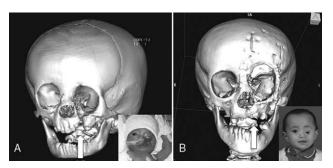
3D CT scans of a patient with left Tessier #4 orbitofacial cleft. A. CT imaging at birth showing the osseous defect (arrow) and communication of the orbit with the maxillary sinus and the oral cavity. B. Postoperative imaging after primary repair using a BMP-2 implant showing bone healing of the maxilla and alveolus (arrow). BMP, bone morphogenetic protein; CT, computed tomography.
